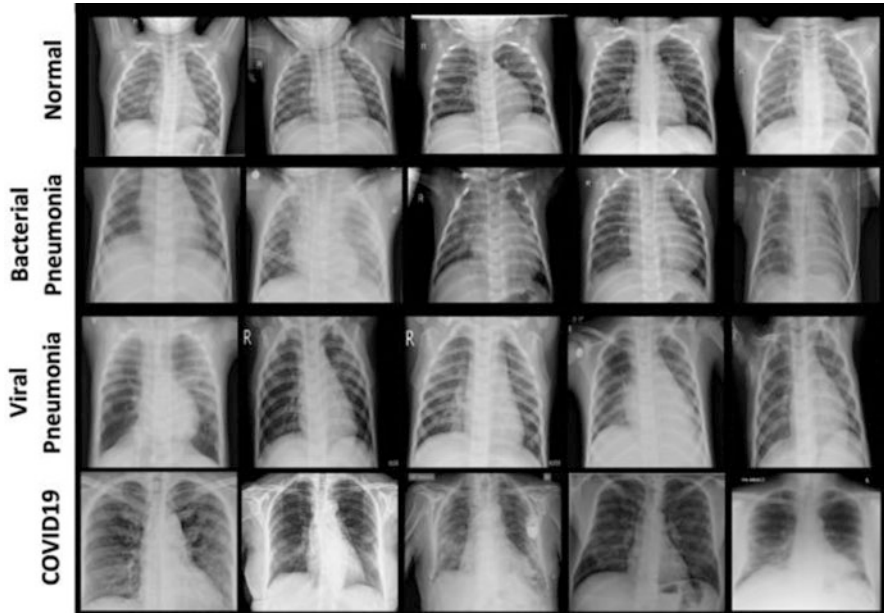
Chest X-ray images of four different classes such as healthy, viral pneumonia, bacterial pneumonia and COVID-19 (Jain et al. 2020)
